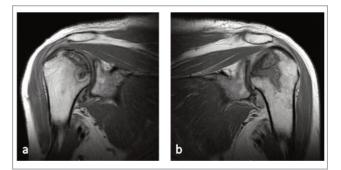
T1-weighted image showing depression of both humeral heads (a and b).
